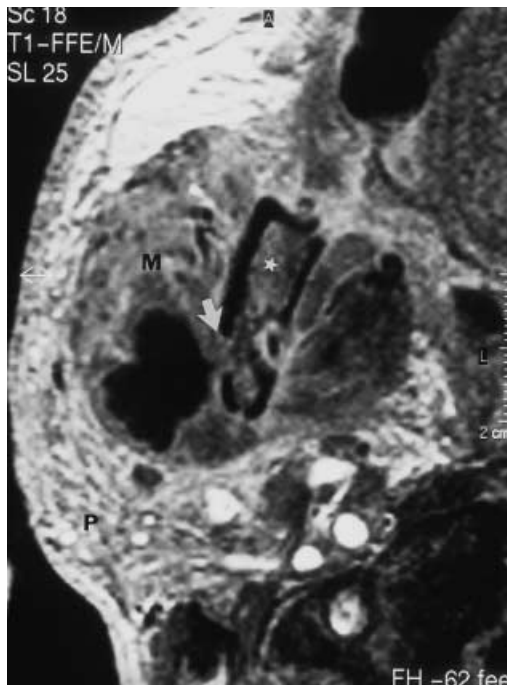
Axial post-contrast T1-weighted 3D fast-field-echo image (slice thickness 0.5 mm) shows a hypointense tumor with a narrow neck of tissue (*arrow*) between the right mandible and the posterior part of the right masseter muscle. *M* masseter muscle; *P* parotid gland; *star* mandible; *L* left; *A* anterior
